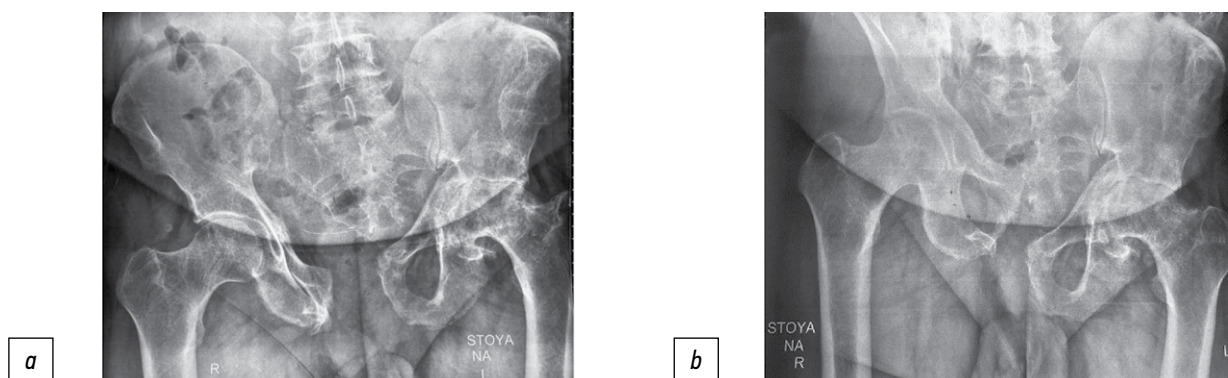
Functional radiography from the pelvis with alternating load on the left and right lower extremities. *a* — standing on the left leg; *b* — standing on the right leg.
